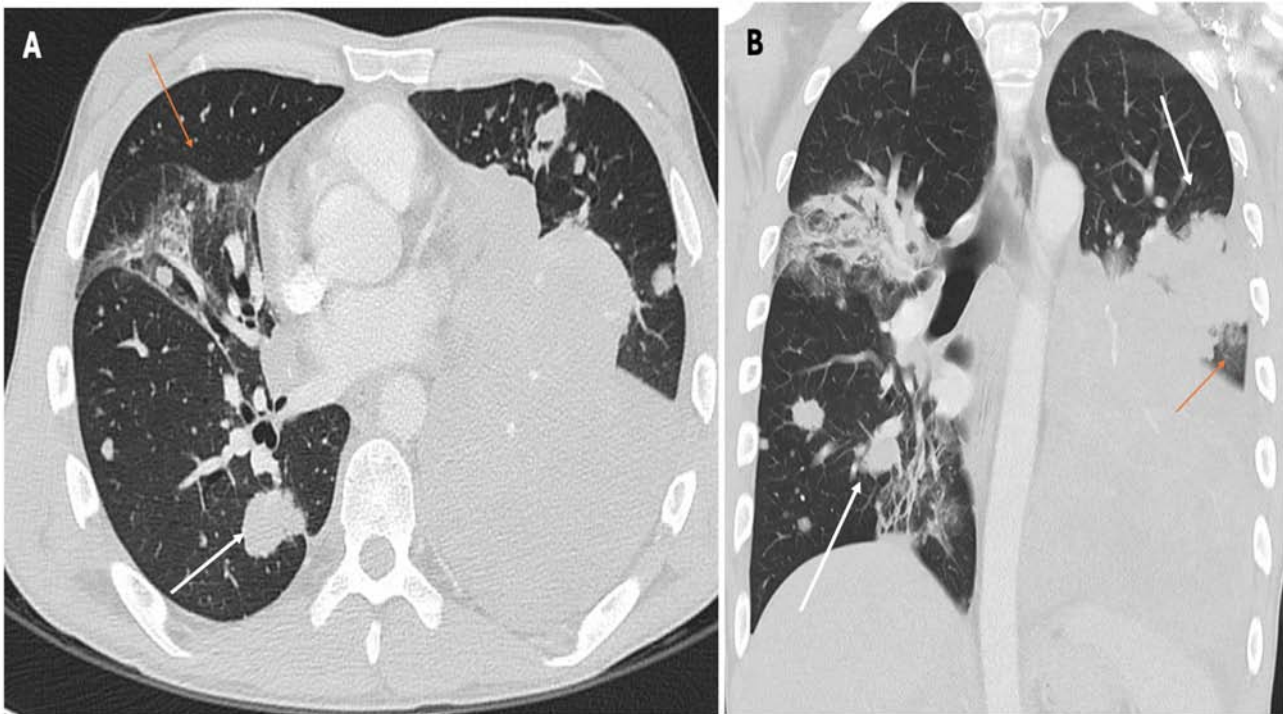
(A) Axial and (B) coronal CT scan with lung parenchyma reconstruction depicting a 58-year-old female patient with metastatic rectal adenocarcinoma with progressing pulmonary metastases undergoing experimental immunotherapy with Nivolumab (see white arrows). Note several areas of increased parenchymal density, predominantly perilesional, characterized by ground-glass opacity (see orange arrows).
